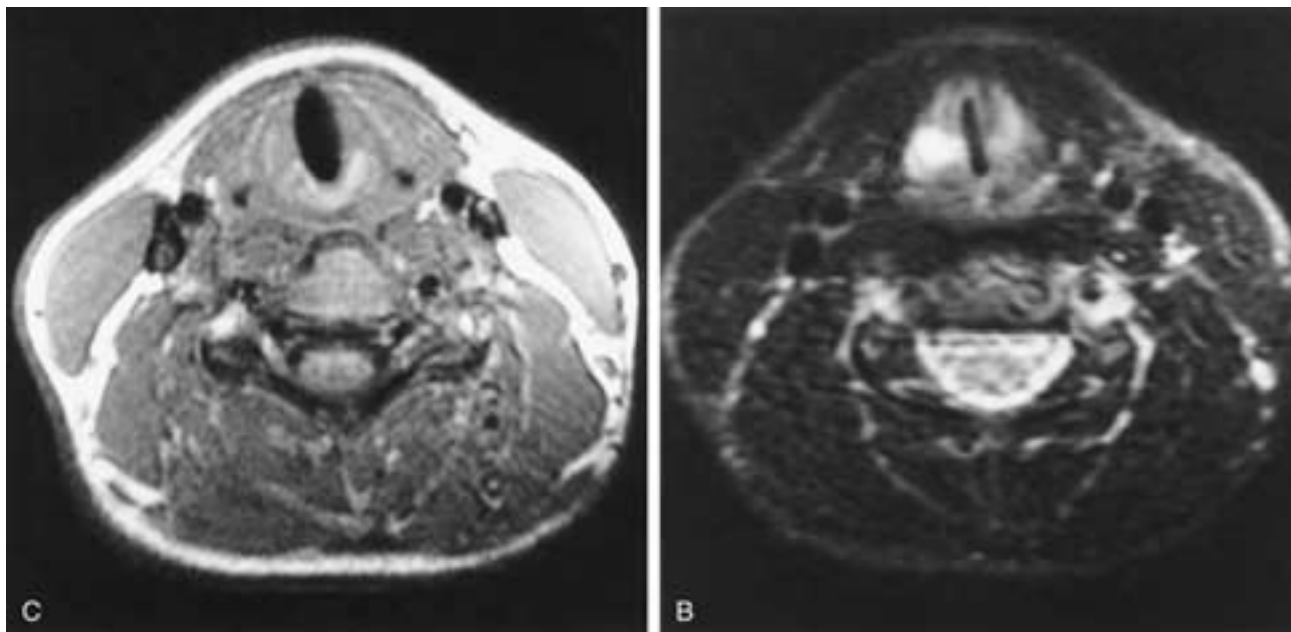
Contusion of the right true vocal cord in a 17-year-old girl who sustained a direct blow to the larynx in an automobile accident and complained of hoarseness. A, T1-weighted axial image shows mild fullness in the right true vocal cord. Note the normal high-signal intensity in the thyroid and cricoid cartilages and the oval contour of the airway. B, T2-weighted image obtained at the same level shows high-signal edema in the true vocal cord.
